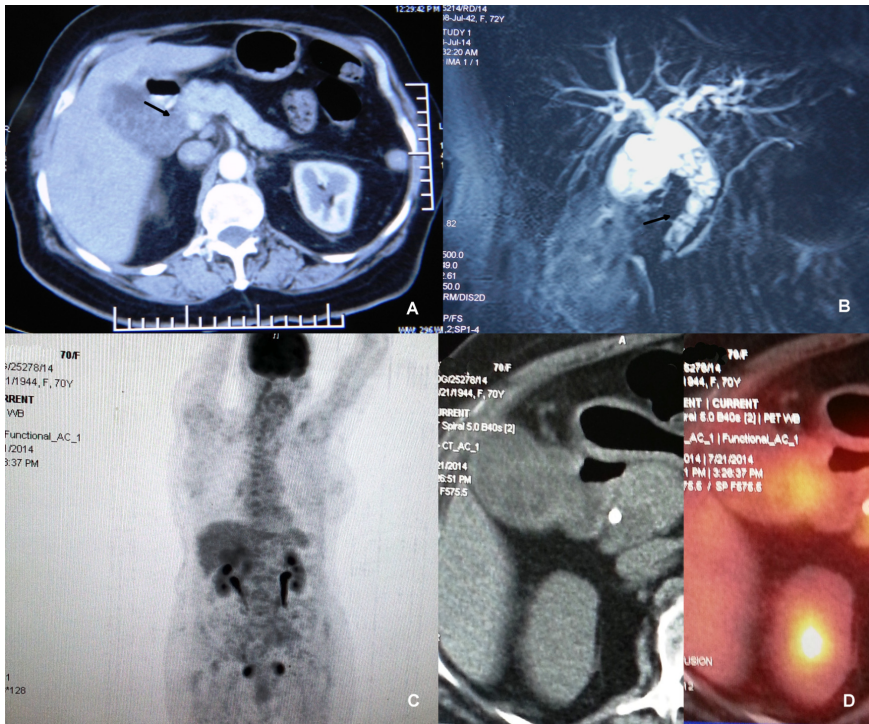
(A) Axial contrast enhanced CT scan image shows distended gall bladder with heterogeneous soft tissue within the lumen (arrow) without calcification. No extra-luminal extension is seen. (B) Magnetic Resonance CholangioPancreatography (MRCP) image shows a heterogeneous septate lesion in the gallbladder with similar appearance in the lower CBD causing dilatation of intrahepatic biliary radicles. No soft tissue component is seen. (C) Coronal PET image showing only mild uptake of FDG in the gall bladder. (D) CT and PET-CT fusion image showing the gallbladder lesion with mild FDG uptake.
